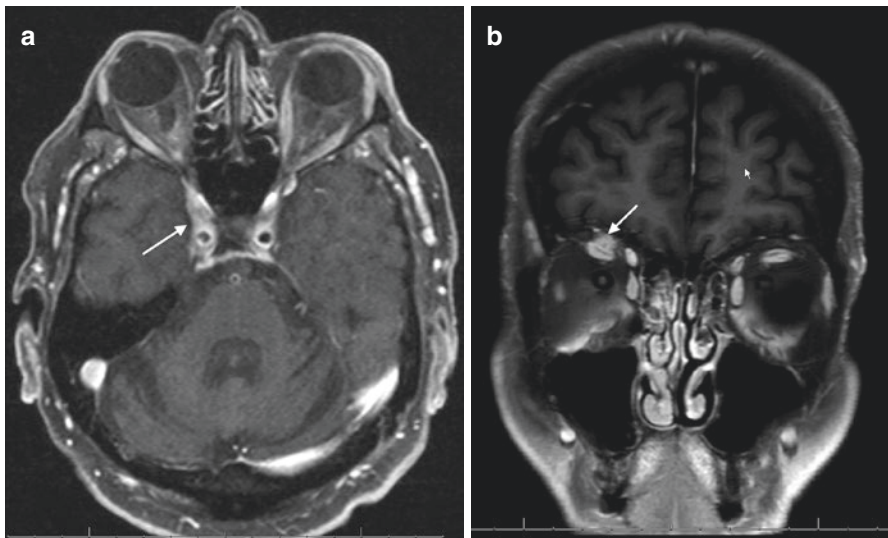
(a) Axial MRI shows widening of the right cavernous sinus compared to the left (*arrow*). (b) Post-contrast Coronal T1 MRI shows enlargement and enhancement of the supraorbital nerve (*arrow*). Note the displacement of the superior rectus inferiorly
